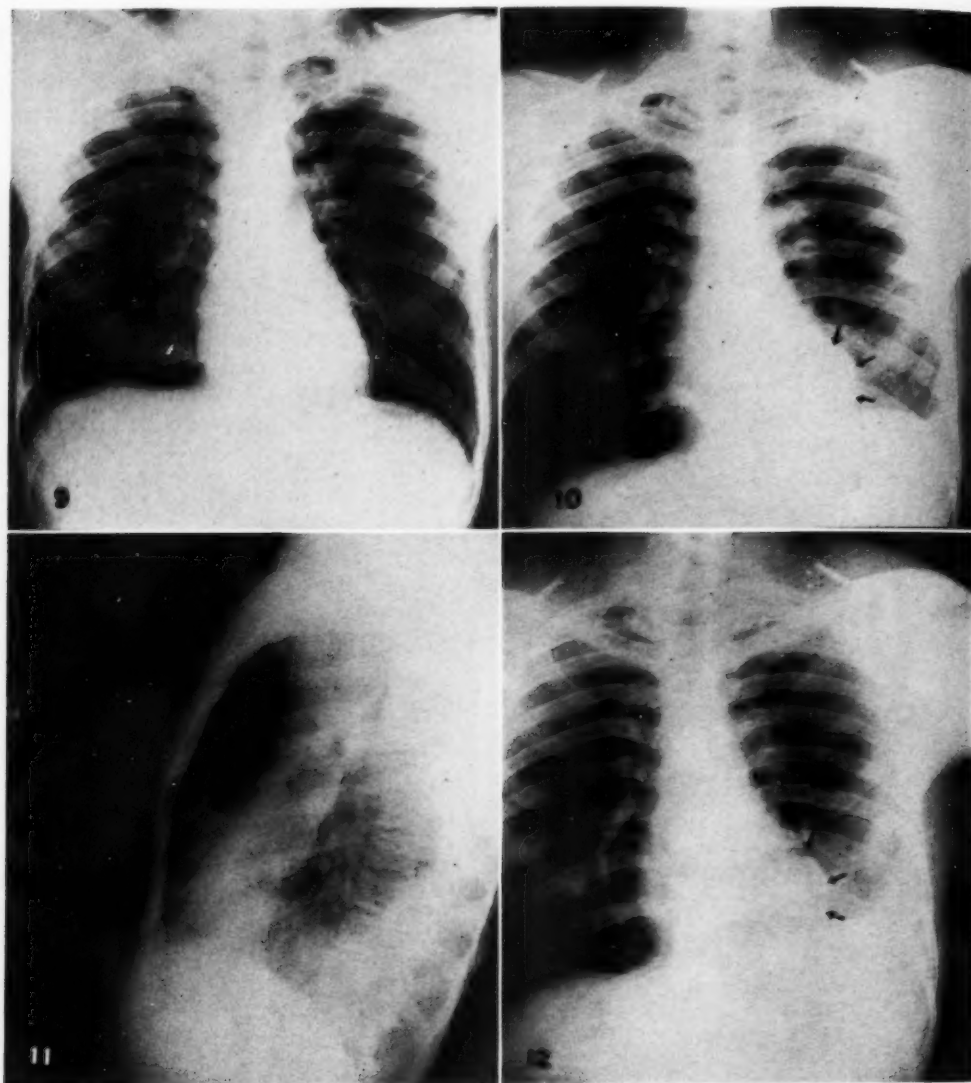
Postero-anterior chest roentgenogram made on the day of admission, Feb. 23, 1950, showing a left pleural effusion and an apparent left mediastinal tumor.
